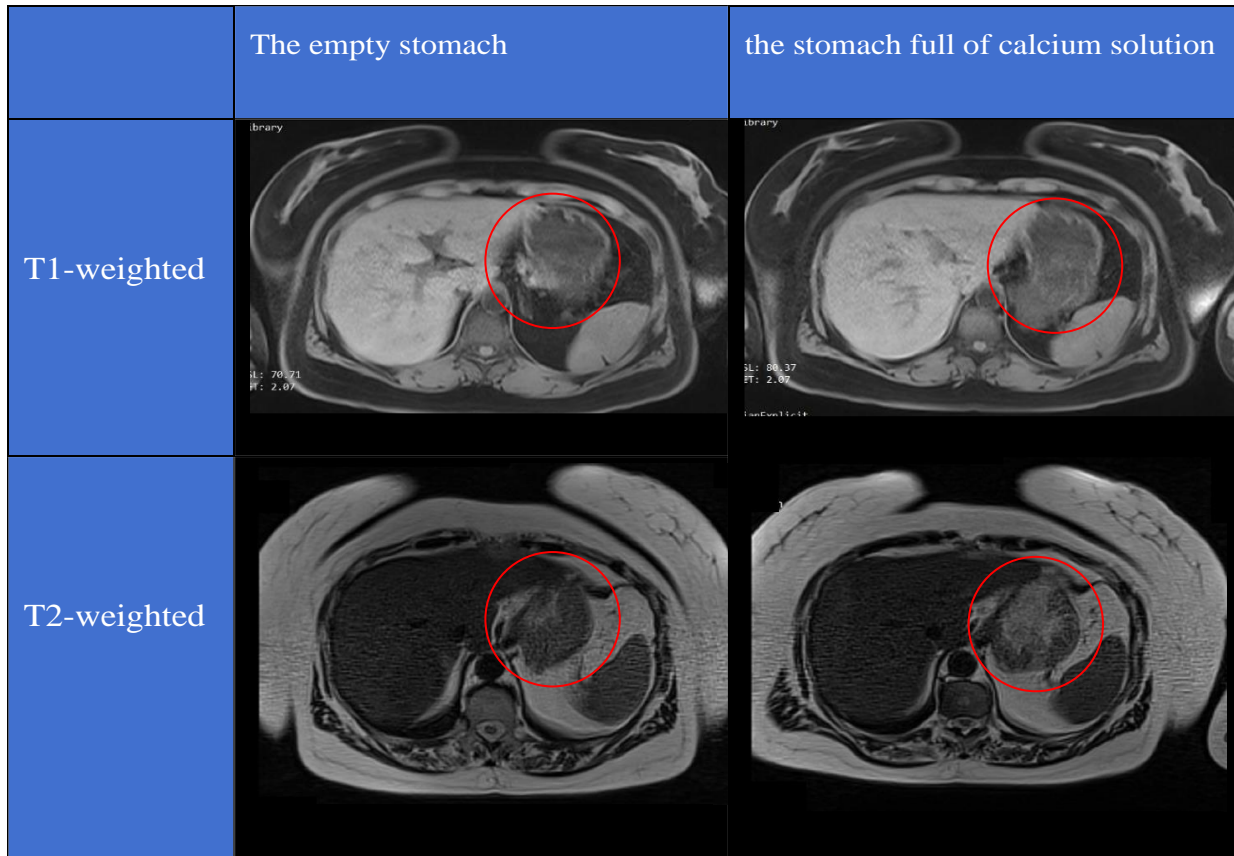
Transverse abdominal MRI for an empty stomach and a stomach full of calcium solution
